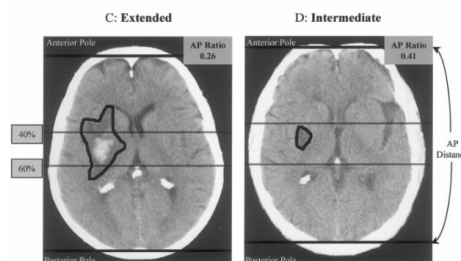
Classification of lesions with CT Analysis(B)
